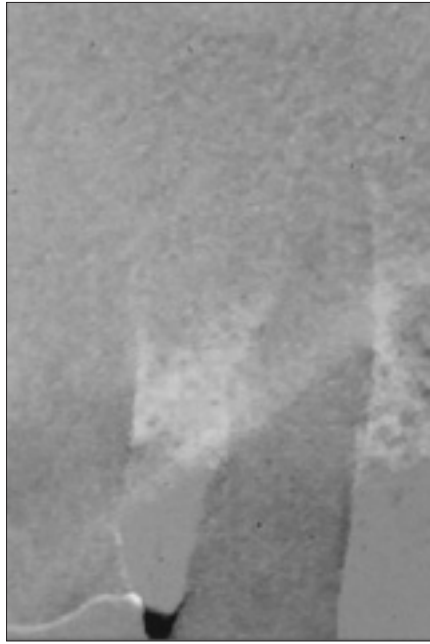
Subtraction radiography showing bone loss (white areas) that has occurred since the last radiographic examination (Fig. 3a).
